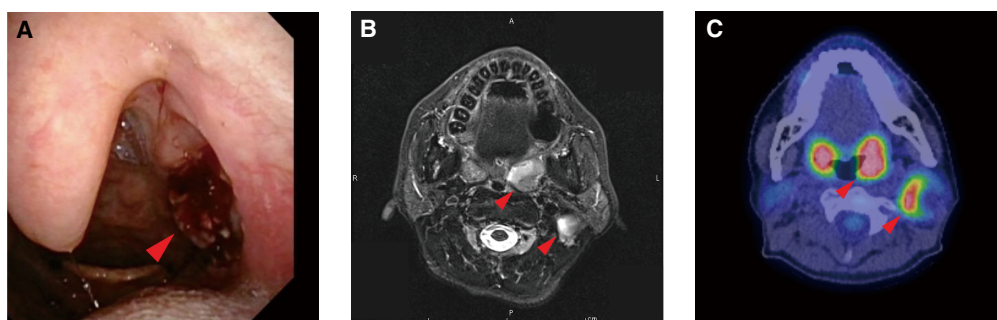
Clinical images of the patient with human papillomavirus (HPV)-related oropharyngeal carcinoma (OPC) in this study. (A) A fiberscopic image of the primary tumor in the left tonsil (red arrowhead). (B,C) Postcontrast T1-weighted magnetic resonance imaging (MRI; B) and positron emission tomography performed with 2-[fluorine-18]fluoro-2-deoxy-d-glucose (FDG-PET; C) revealed a left tonsillar mass and left cervical lymphadenopathy in the level II region (red arrowhead).
